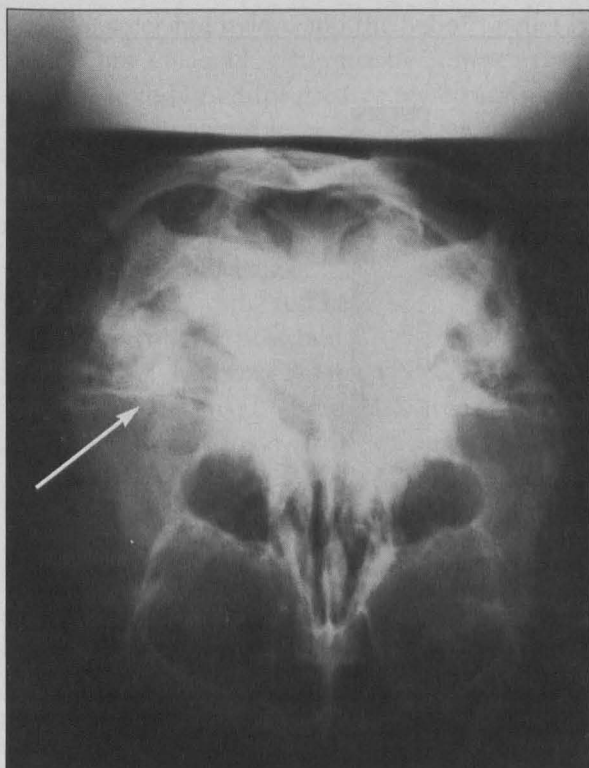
Anteroposterior plain film of skull showing location of BB.
